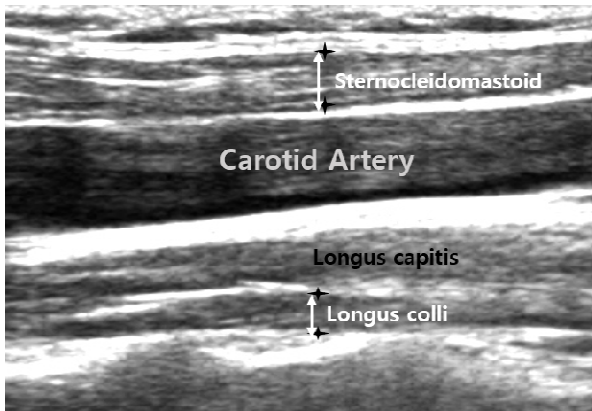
Ultrasonographic image of the sternocleidomastoid and longus colli muscles.
